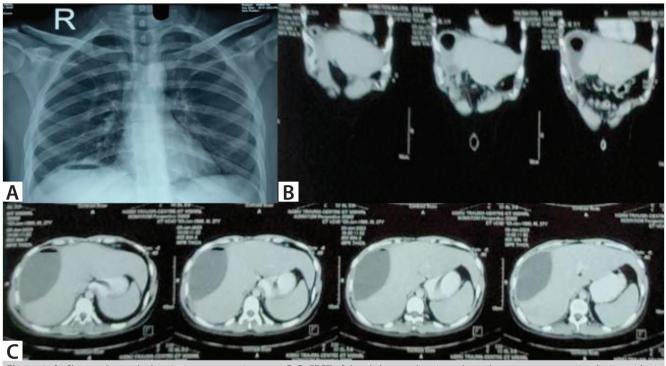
A. Chest radiograph showing pneumoperitoneum. B,C. CECT of the abdomen showing a hypodense space-occupying lesion with air specks and air-fluid levels.
